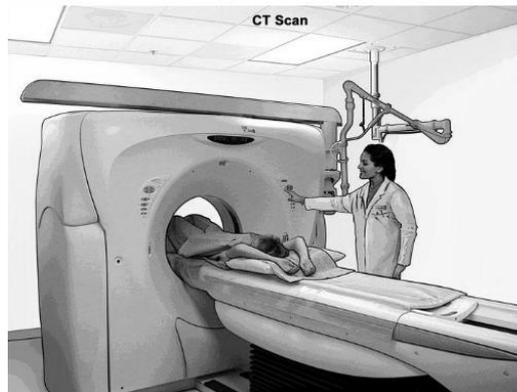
Abdominal CT Scan performed on a patient [13]
